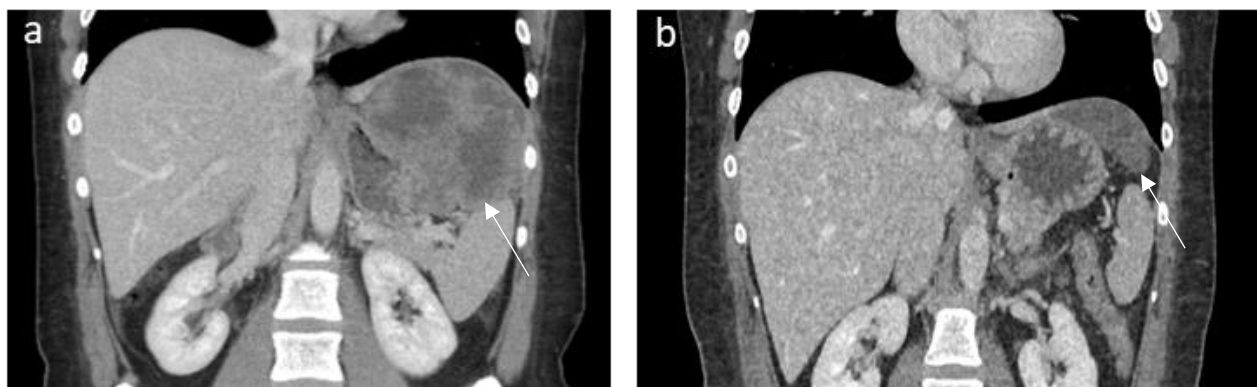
a) Coronal portal venous phase CE-CT image of a 46-year-old female diagnosed with an intermediate-risk gastric GIST (arrow). b) A substantial reduction in tumour size (arrow) was observed after 11.8 months of neoadjuvant TKI treatment, which was considered surgically beneficial.
